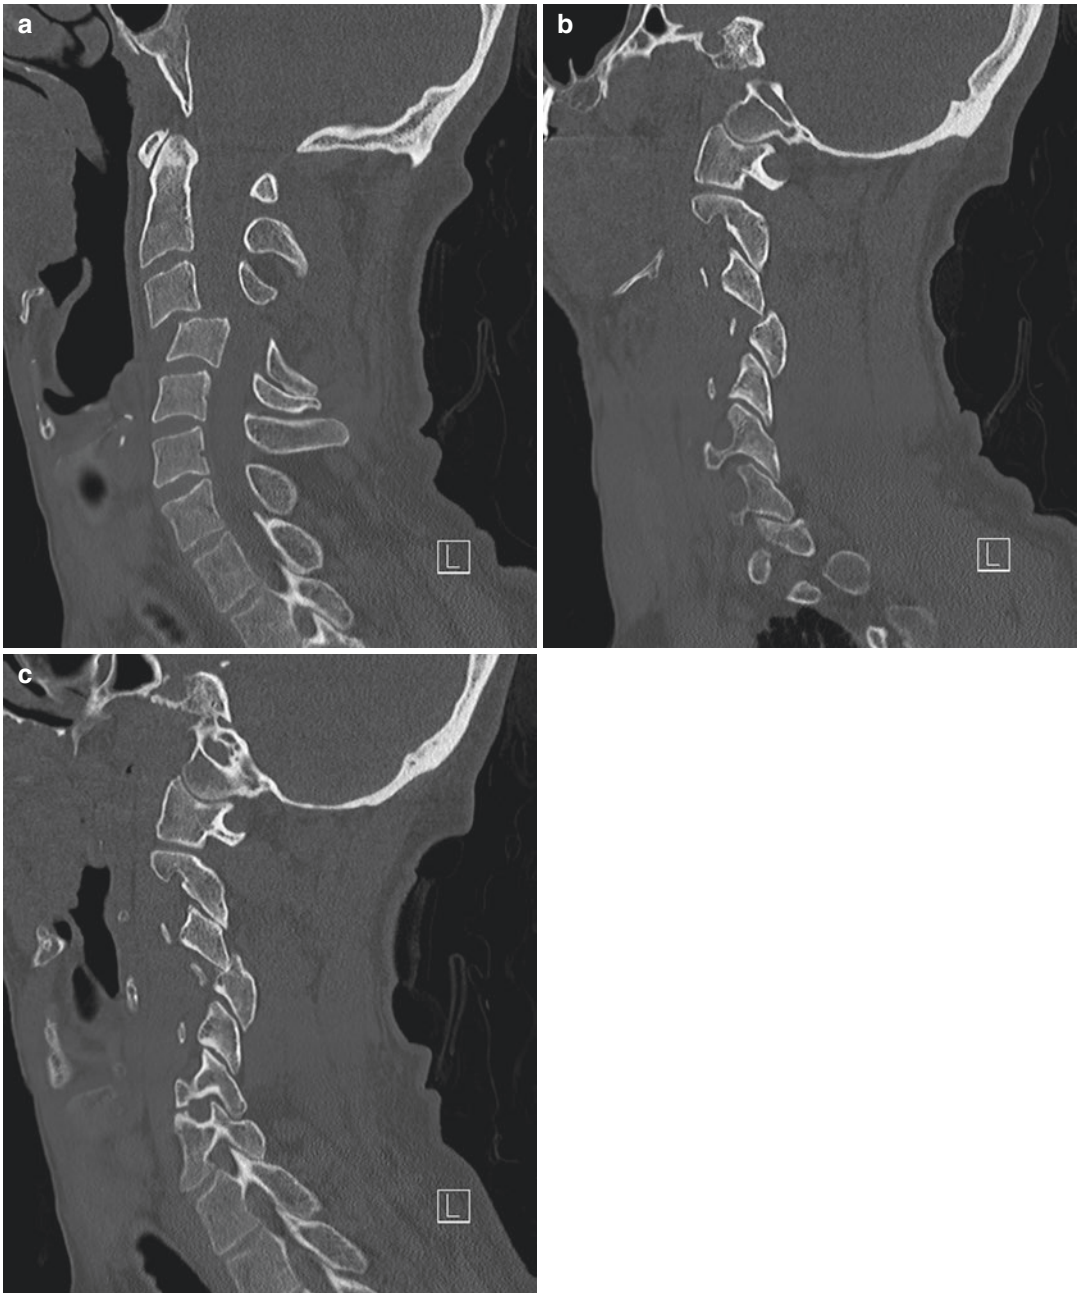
(a) Midsagittal CT showing bifacet dislocation (producing approximately 50% anterolisthesis) plus parasagittal views showing (b) left- and (c) right-sided facet dislocations
